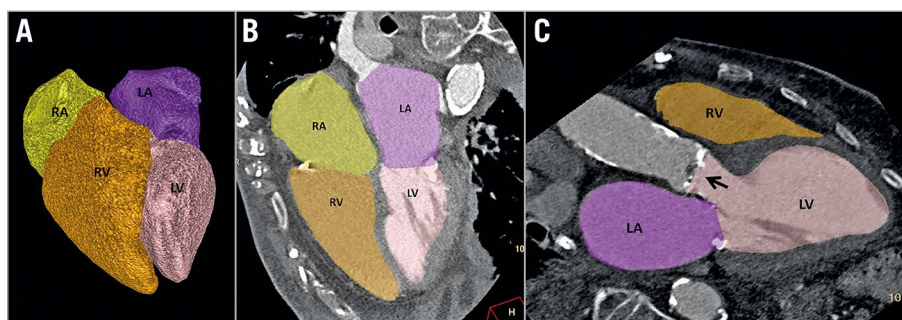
Output example of the fully automated four-chamber volumetric analysis of the pre-TAVR cardiac CT angiography showing an enlarged right ventricle (right ventricular volume index = $127.4 \text{ mL}/\text{m}^2$). A) Volumetric model of the four cardiac chambers. B) Vertical long-axis reformation (four-chamber view). C) Oblique (three-chamber view). Arrow showing the calcified aortic valve. Colour code: left atrium = purple, left ventricle = pink, right atrium = yellow, and right ventricle = orange. LA: left atrium; LV: left ventricle; RA: right atrium; RV: right ventricle
